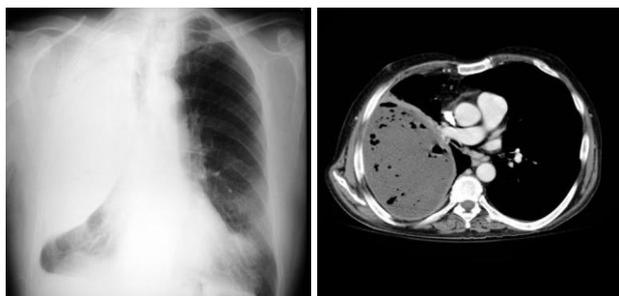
Radiological & CT of Empyema
